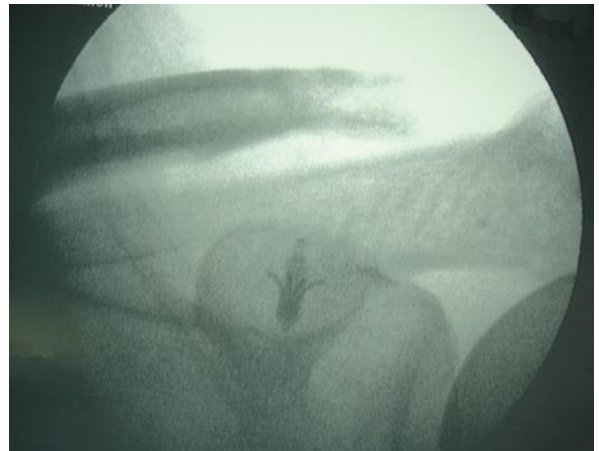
Intraoperative x-ray status-post suture anchor fixation and distal clavicle excision secondary to acromioclavicular joint degeneration.
